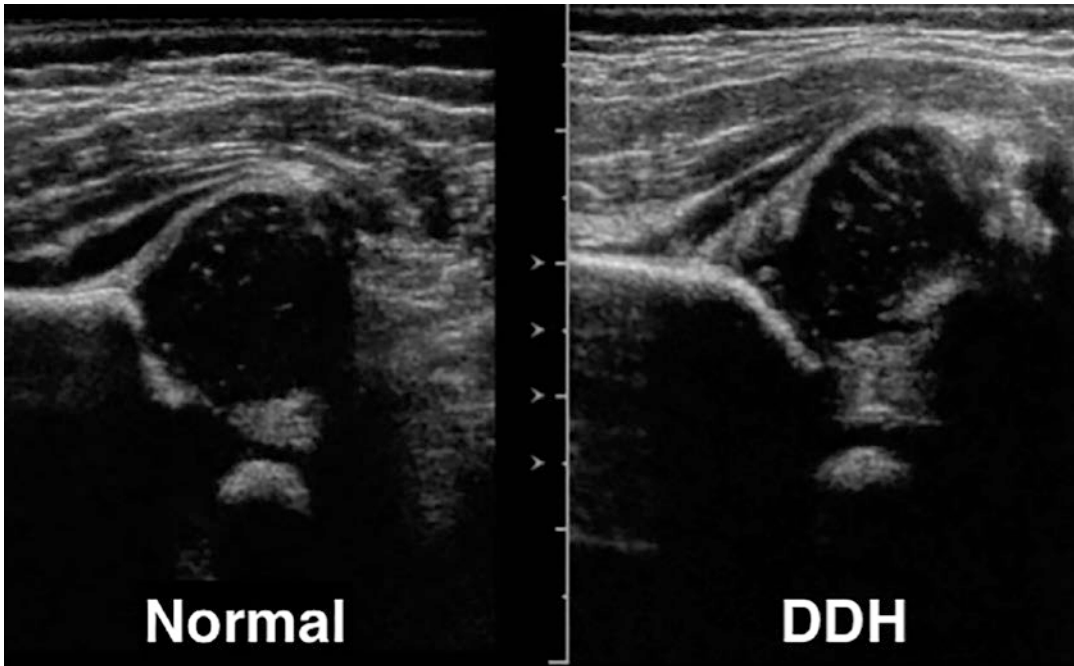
Normal and DDH at ultrasound examination
